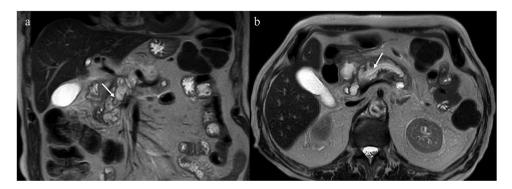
Coronal (A) and axial (B) magnetic resonance T2-weighted images reveal a diffuse dilation of the main pancreatic duct (arrows), with hyperintense luminal content. Some associated cystic lesions are also seen throughout the pancreas.
